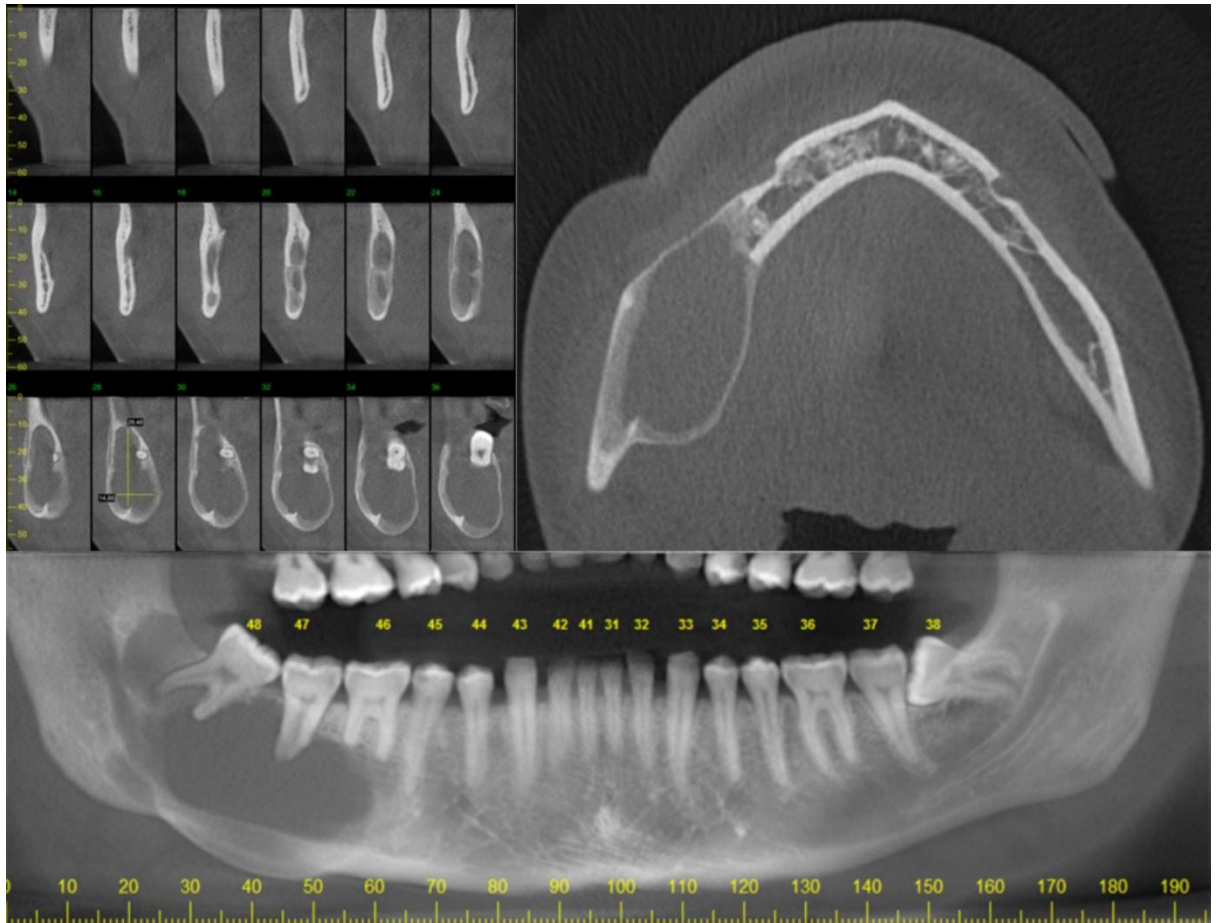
Preoperative CT scan.
